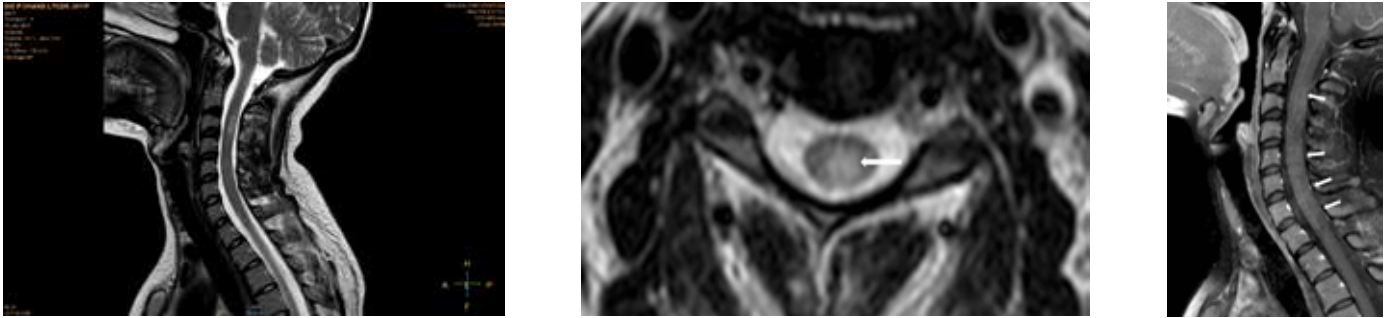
MRI- TSE T2 sagittal (a) section of the cervical cord shows focal areas of hyperintense signal intensity within the spinal cord. These areas were hyperintense on STIR and isointense on T1WI; (b) Axial section at level of the cranial lesion shows predominant involvement of dorsal and lateral columns (white arrow); (c) Post contrast TSE T1 FS Sag section shows faint patchy enhancement of large segment of the cervical spinal cord (white arrows)
